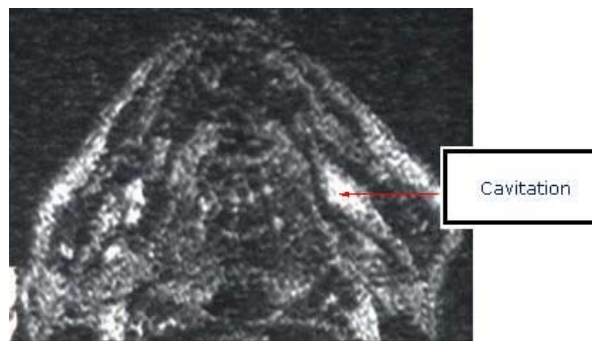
MRI STIR image and Cavitat scan of the same area, both demonstrating a cavitation in the same area.
